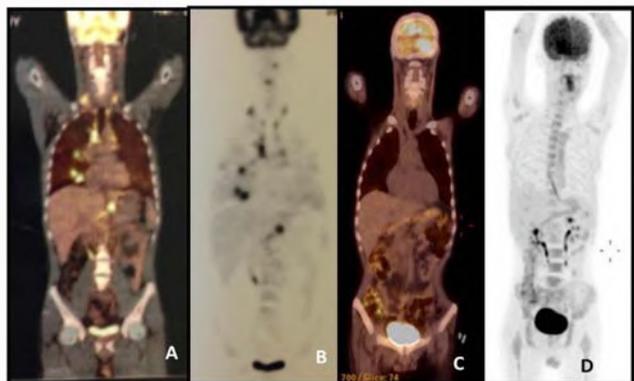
A & B) FDG avid-mass on right hilum with multiple mediastinal lymphadenopathy, multiple lytic metastases to ribs, sacrum, left femur neck, thoracolumbar vertebra and right acetabulum; C & D) Complete regression after crizotinib.
